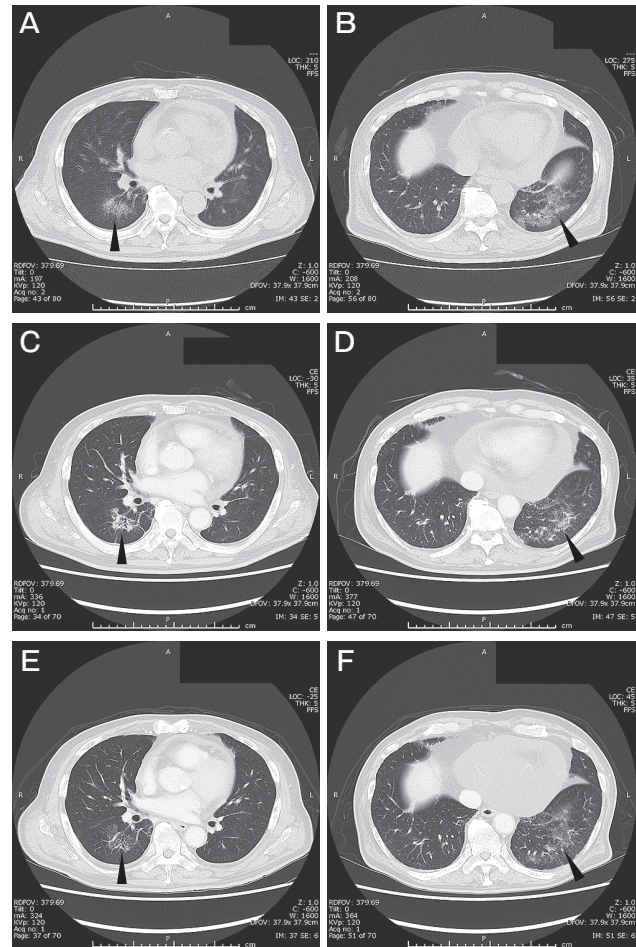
(A, B): The chest computed tomography (CT) findings on day 28 from post-transplant-cyclophosphamide-based haploidentical stem cell transplantation (PTCY-haplo-SCT), showing ground-glass opacities (GGOs) in both lungs (arrowheads). (C, D): Chest CT findings on day 39, showing enhancement of the GGOs resembling organizing pneumonia (OP) (arrowheads). (E, F): Chest CT findings on day 83, showing regression of GGOs (arrowheads).
